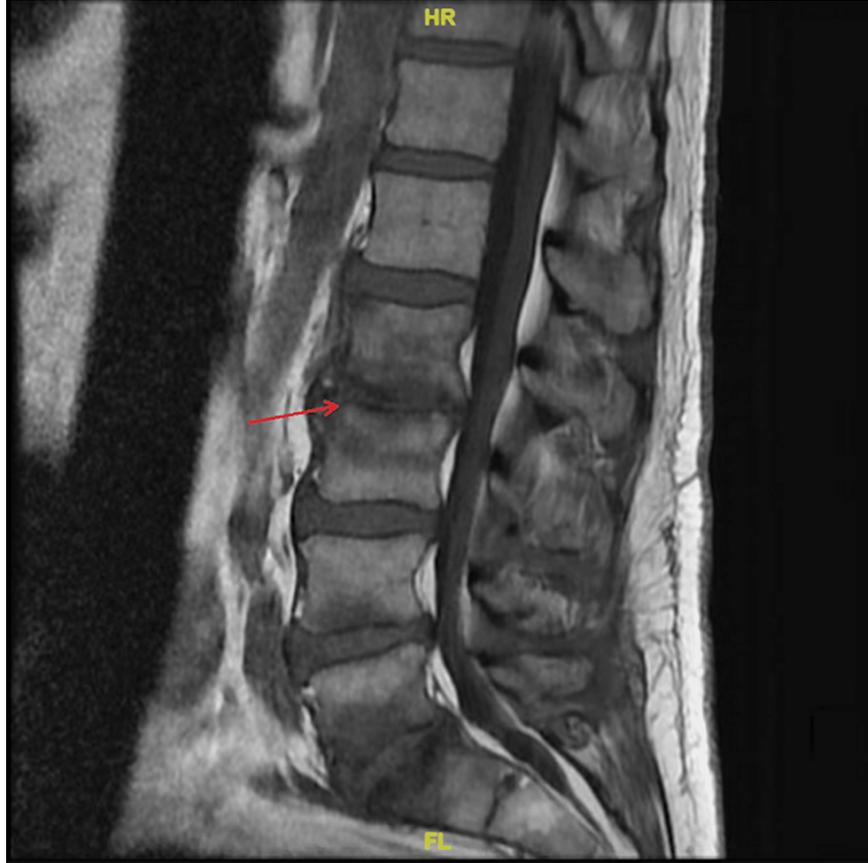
T1 sagittal MRI L-spine. Red arrow at the L4-L5 level demonstrates marked marrow signal changes suggestive of osteomyelitis/discitis
